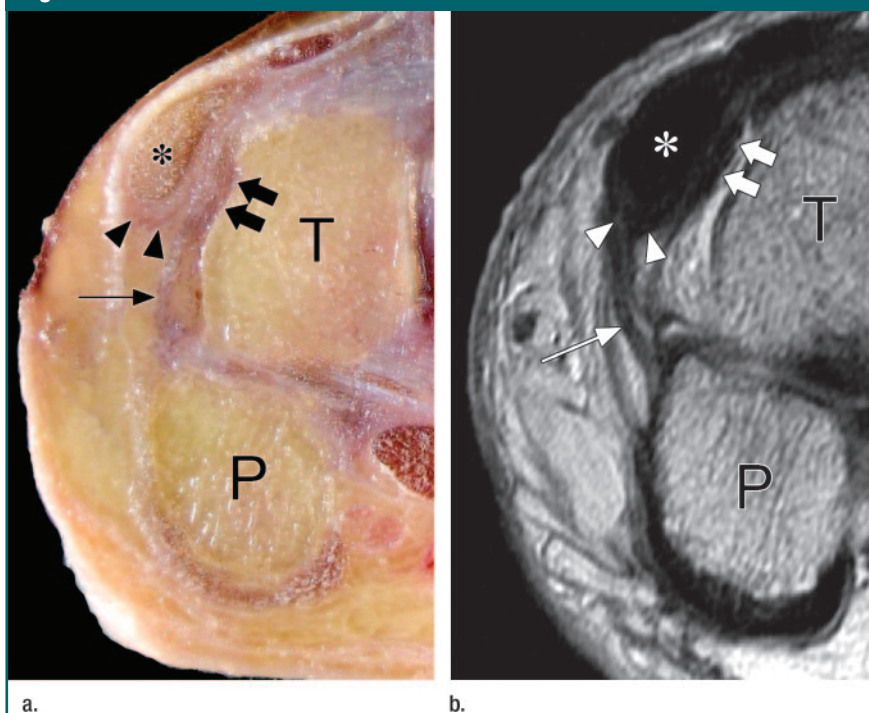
(a) Gross anatomic section and (b) corresponding intermediate-weighted MR image show anatomic features of the distal insertion of the UMH in the transverse plane at the level of the pisotriquetral joint. The fibers at the main insertion into the ulnar aspect of the triquetrum (T, thick arrows) are recognized between the triquetrum and the ECU tendon (*). Some fibers extend further distally (arrowheads) to the base of the ulnar aspect of the hamate bone and the fifth metacarpal bone and are volar to the ECU tendon. In addition, some fibers attach to the ulnar aspect of the pisiform (P), forming the dorsal capsular ligament of the pisotriquetral joint (thin arrow).
